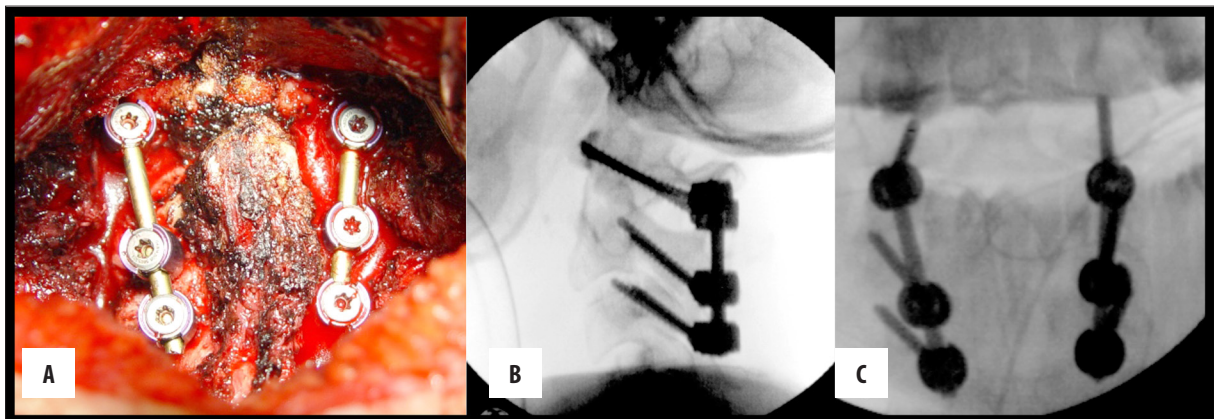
Postoperative radiograph with complete fixation construct C1–C3 intraoperatively (A), and in a radiographically lateral (B) and anterior-posterior (C) view.
